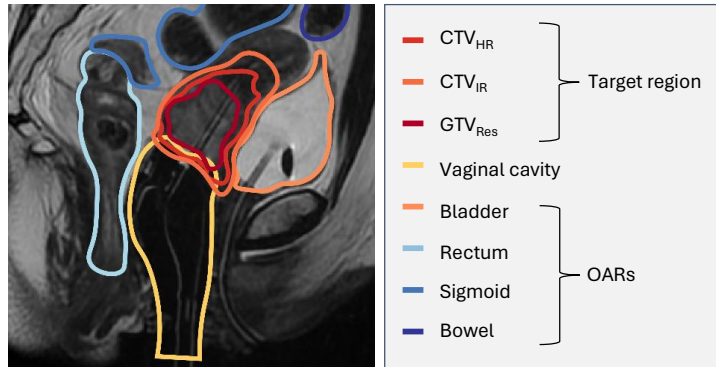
Delineation of regions of interest on a sagittal T2 weighted MR image.
